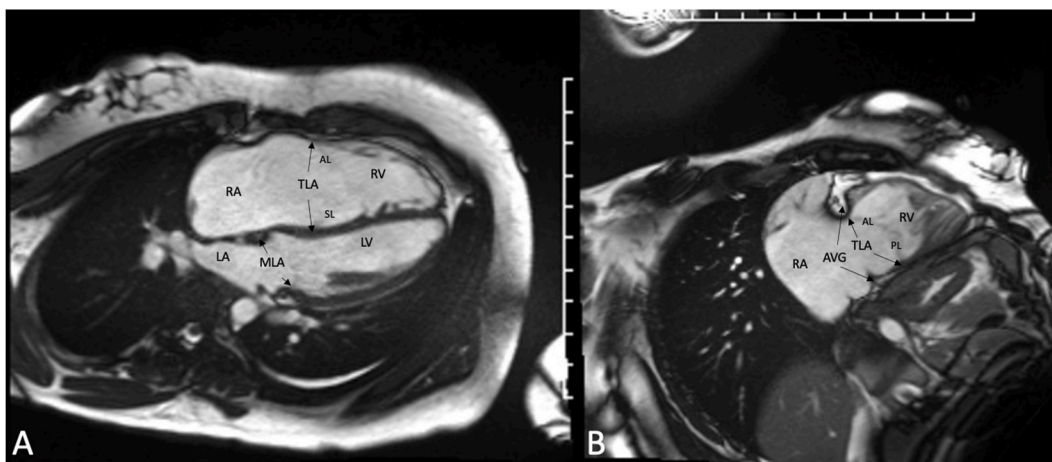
Cardiac Magnetic Resonance Imaging: Distorted Anatomy. See bright blood cine images in four chamber (Panel A) and RV long axis (Panel B) views demonstrating distorted intracardiac anatomy with apical displacement of the tricuspid septal and posterior leaflet attachments leading to a severely enlarged right atrium and a small right ventricle. Abbreviations: AL: anterior leaflet; AVG: atrioventricular groove; LA: left atrium; LV: left ventricle; MLA: mitral leaflet attachments; PL: posterior leaflet; RA: right atrium; RV: right ventricle; SL: septal leaflet; TLA: tricuspid leaflet attachments.
